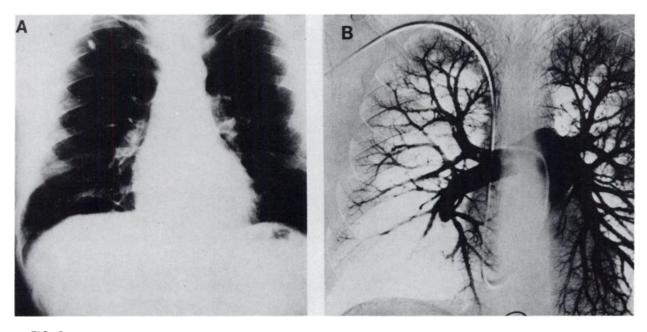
(A) Anteroposterior chest roentgenogram taken on September 26, 1974. No infiltrates or regions of decreased vascularity are evident. Small calcifled scar is noted in right upper lobe. (B)
